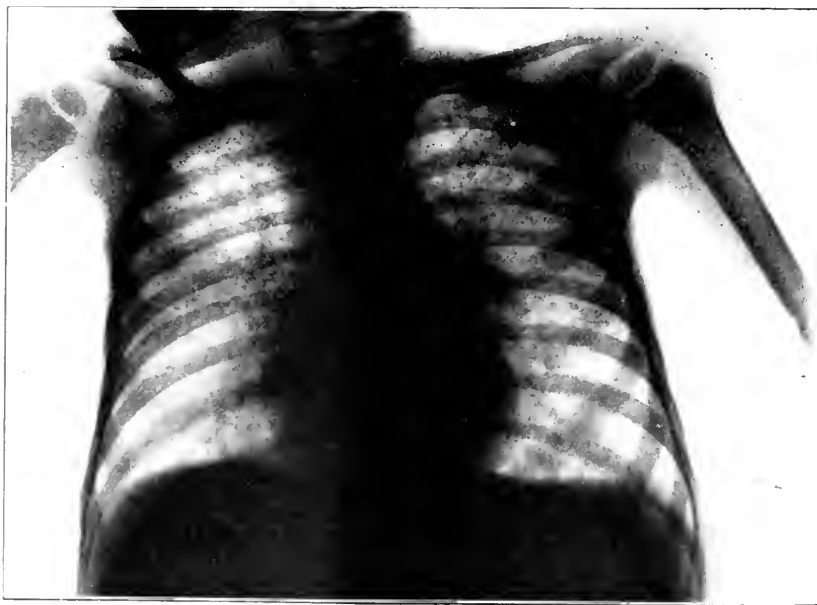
Case 5, miliary tuberculosis. It was thought on admission that the child might be suffering from a diffuse bronchopneumonia. The general course of the disease with the physical signs and the roentgenogram pointed clearly to a pulmonary, and probably a general, miliary tuberculosis.
